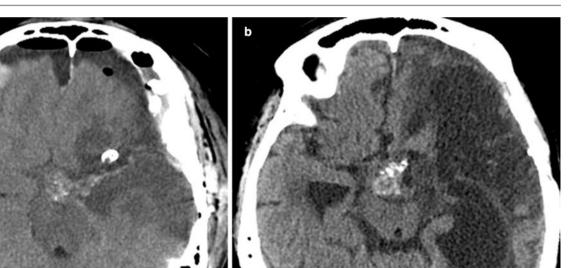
Computed tomography 2 days (a) and 4 years (b) after partial removal of a craniopharyngioma complicated by intraoperative injury and complete sacrifice of the left internal carotid artery demonstrate a large infarct in the left cerebral hemisphere
